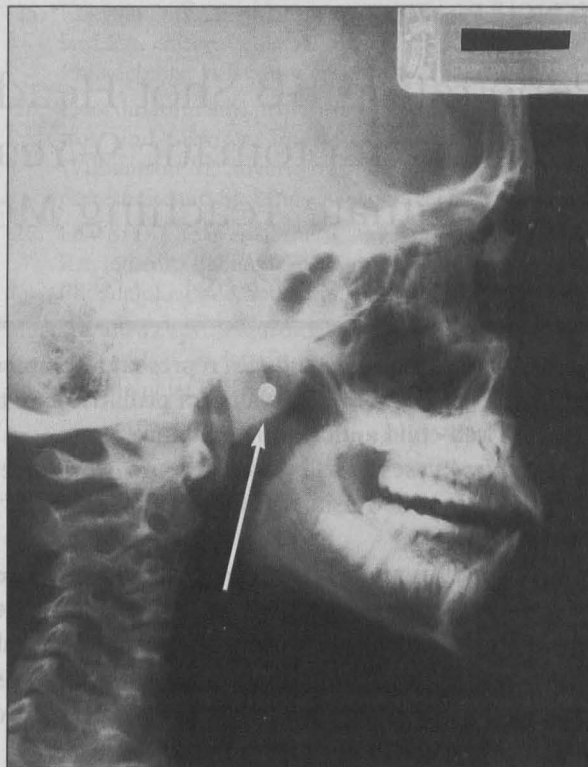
Lateral plain film view of skull showing location of BB.
